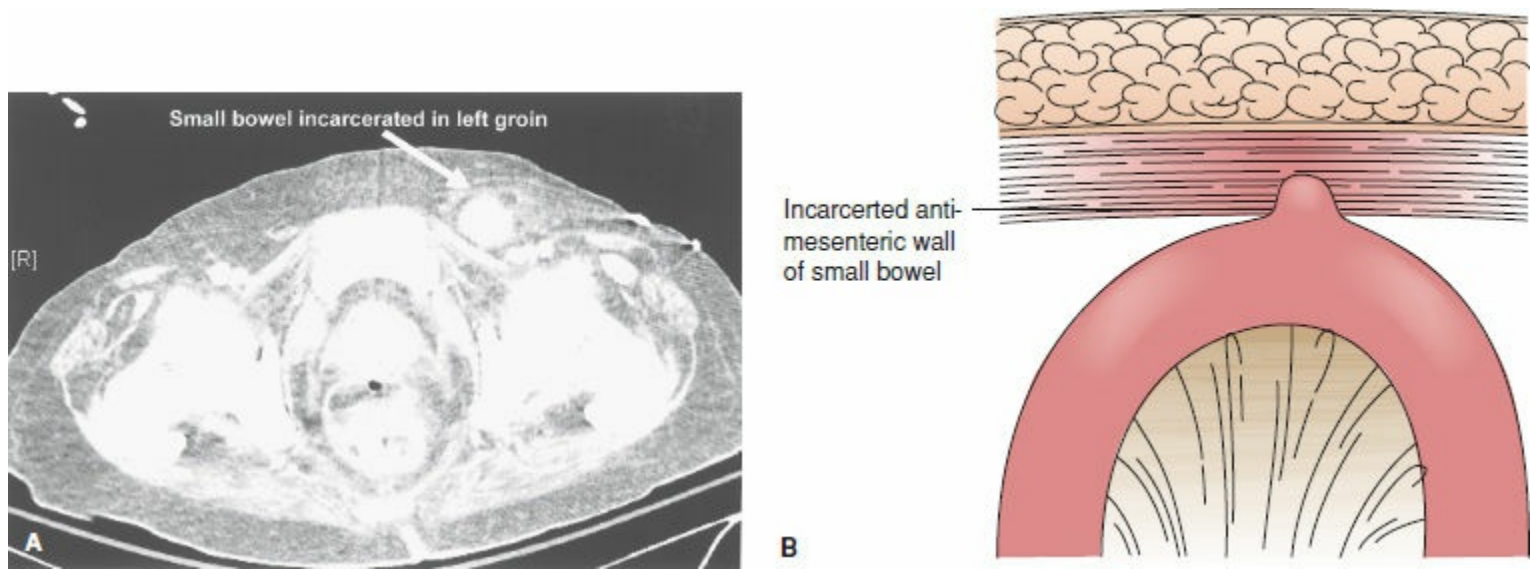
Richter hernia. A: Computed tomography scan showing contrast and air in the incarcerated segment within the left
